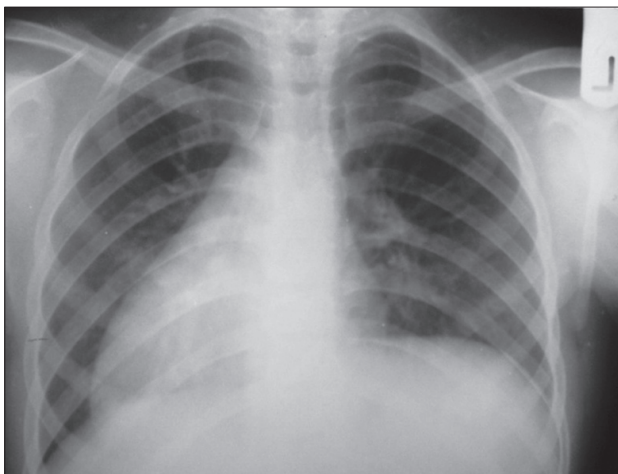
Chest X-ray of case 1 showing dextrocardia
